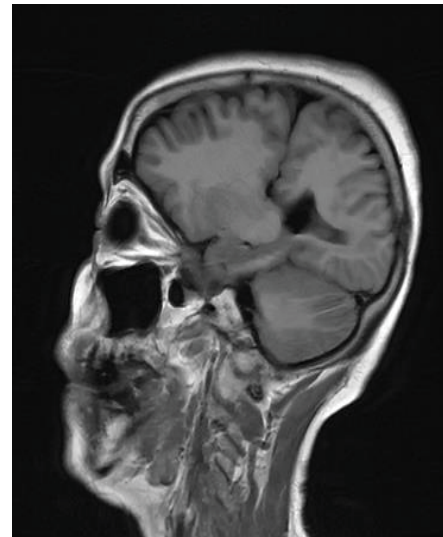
Magnetic resonance, T1-weighted images, sagittal section, showing the left frontal sulcus widened and communicated with the left ventricle, and without showing the septum pellucidum.
